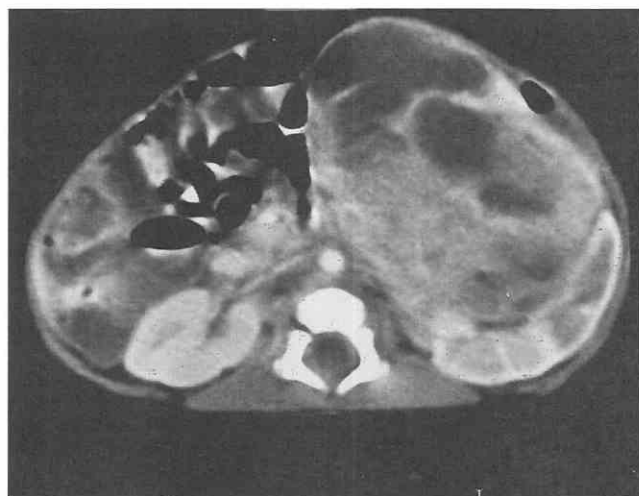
Congenital mesoblastic nephroma in a 1-day-old male infant. Contrast-enhanced CT axial image through the kidneys. Enhancing renal parenchyma is visible splayed around the posterior and inferior margins of a very large, partially necrotic mass arising from the upper pole of the left kidney.
